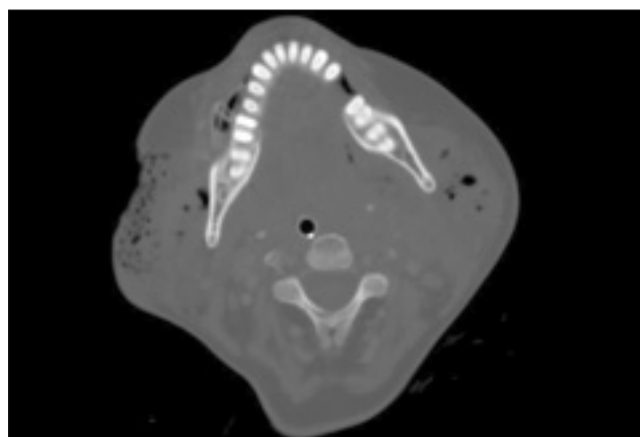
Preoperative CT scan showing marked edema and extensive subcutaneous gas formation, which is also present in the parotid gland bilaterally.
